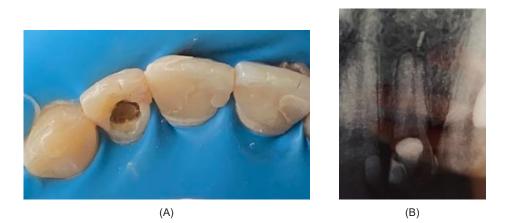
(A) Cavity access for retreatment; (B) Post-retreatment periapical radiographs showed that there was still gutta percha that had not been collected
